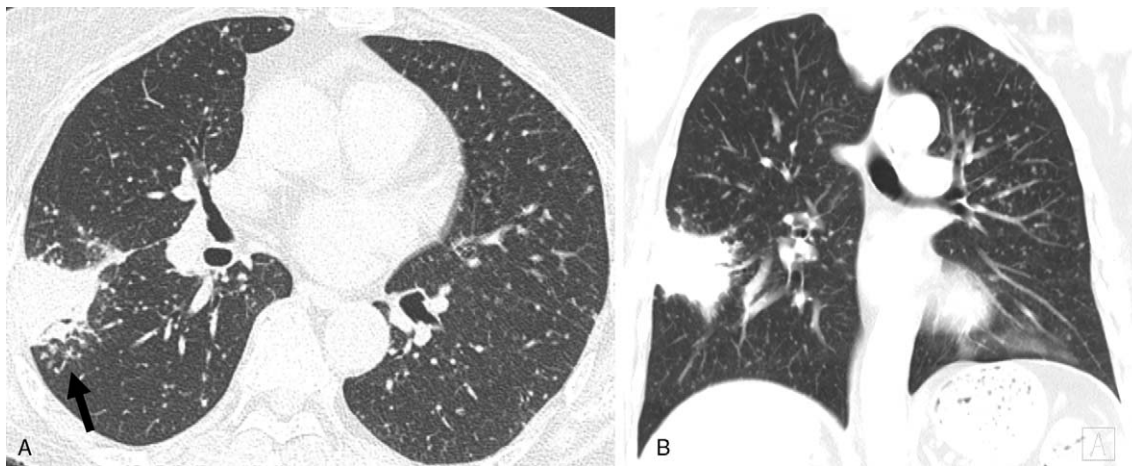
67-year-old woman with missed miliary TB. Miliary TB in a 67-year-old woman who was admitted to hospital with persistent fever. (a) A lung window of an axial CT (1.0 mm section thickness) shows irregular mass-like consolidation in the right lower lobe superior segment and surrounding centrilobular nodules with branching opacities, showing tree-in-bud appearance (arrow). (b) A lung window of a coronal CT (5 mm section thickness) shows multiple well-defined randomly distributed micronodules, predominantly 2–4 mm in size, in both lungs. Miliary TB was missed on the initial CT reading at symptom onset. Mass-like consolidation in the right lower lobe was misinterpreted as a primary lung cancer, and miliary nodules were interpreted as metastasis. Centrilobular nodules with tree-in-bud appearance located in locations typical of secondary TB were neglected and not interpreted appropriately.
